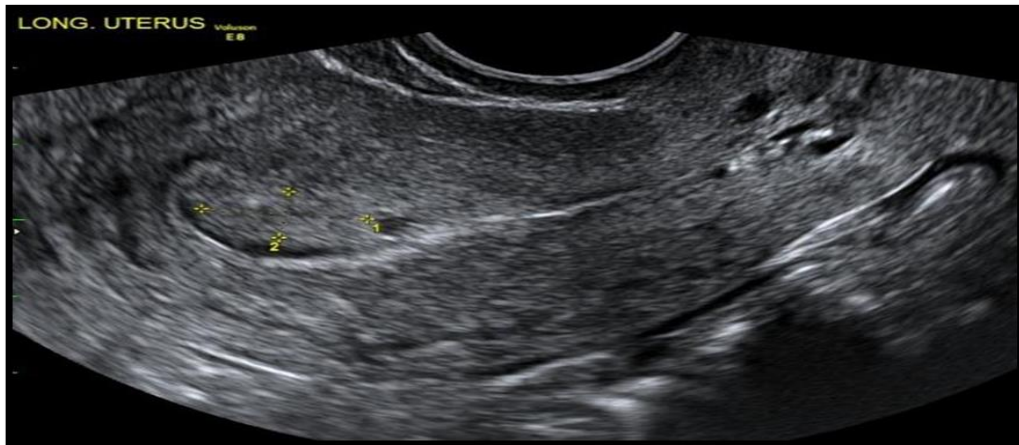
Transvaginal ultrasound demonstrates a polyp within the endometrial cavity. Radiopaedia
